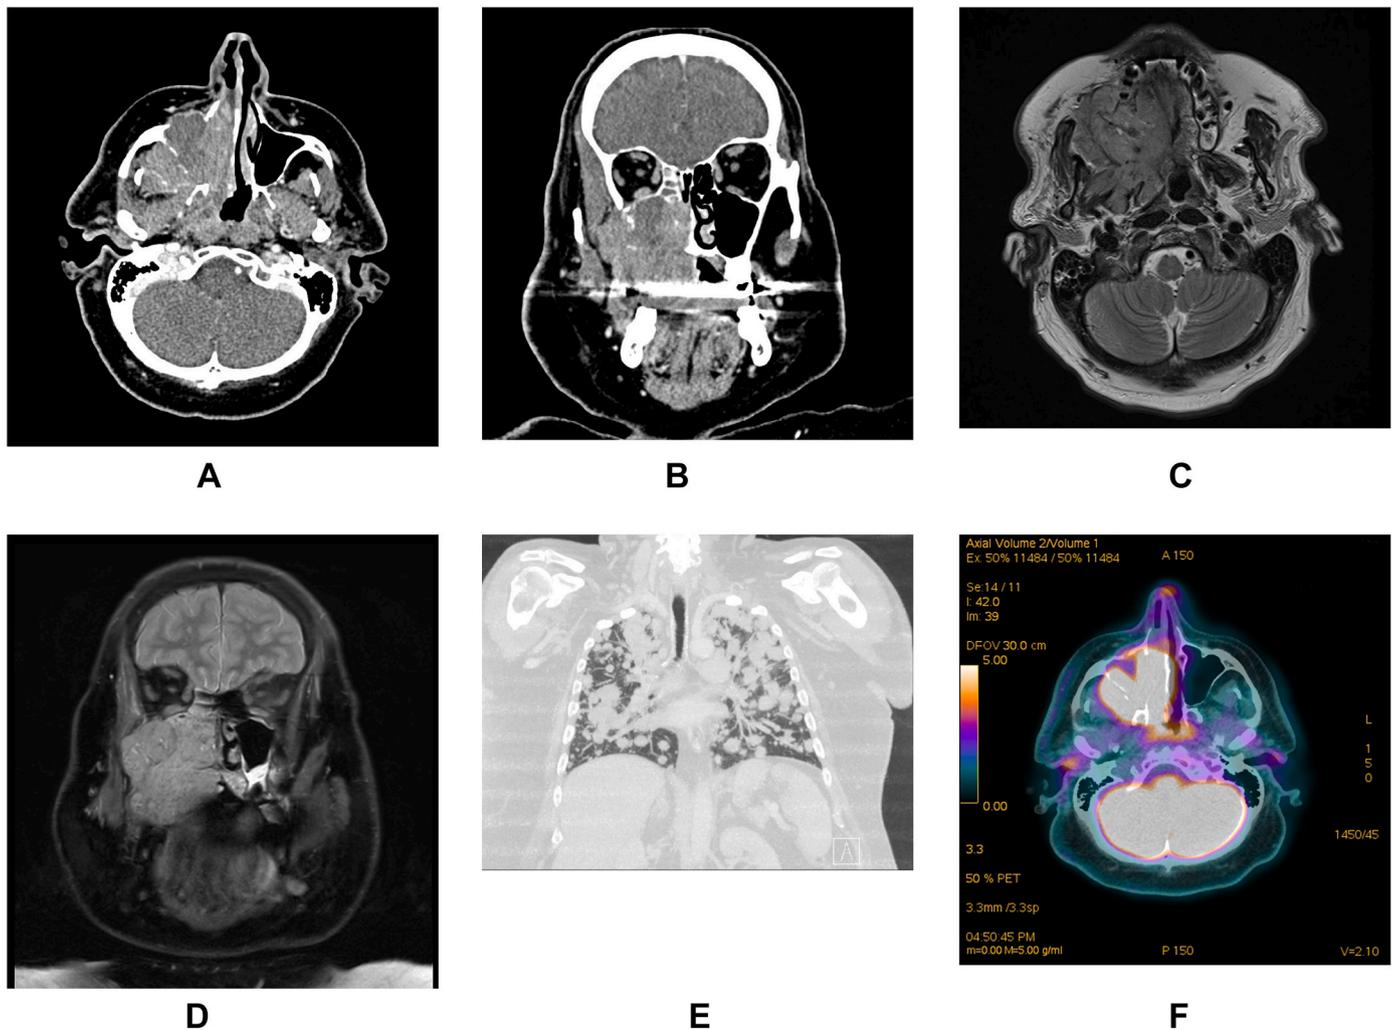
Patient from the Besancon center, with a T4c oral mucosal melanoma of the maxilla, with lung metastases at diagnosis. Axial (A) and coronal (B) head and neck CT scans, and axial (C) and coronal (D) T1 MRI images show the extent of the neoplasm. (E) Thoracic CT scan showing multiple lung metastases. (F) PET/CT scan of the lesion.
